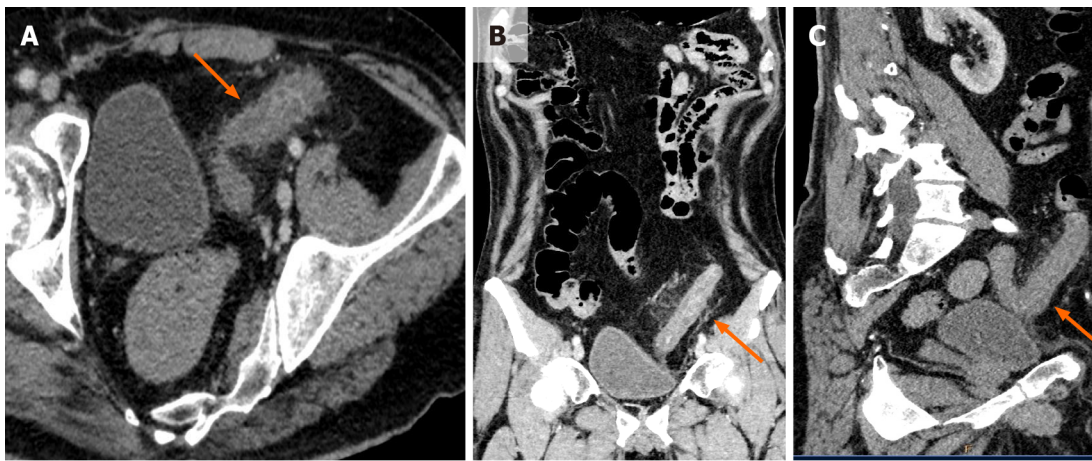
Contrast enhanced computed tomography imaging in a patient with coronavirus disease 2019 presenting with bloody diarrhea.
